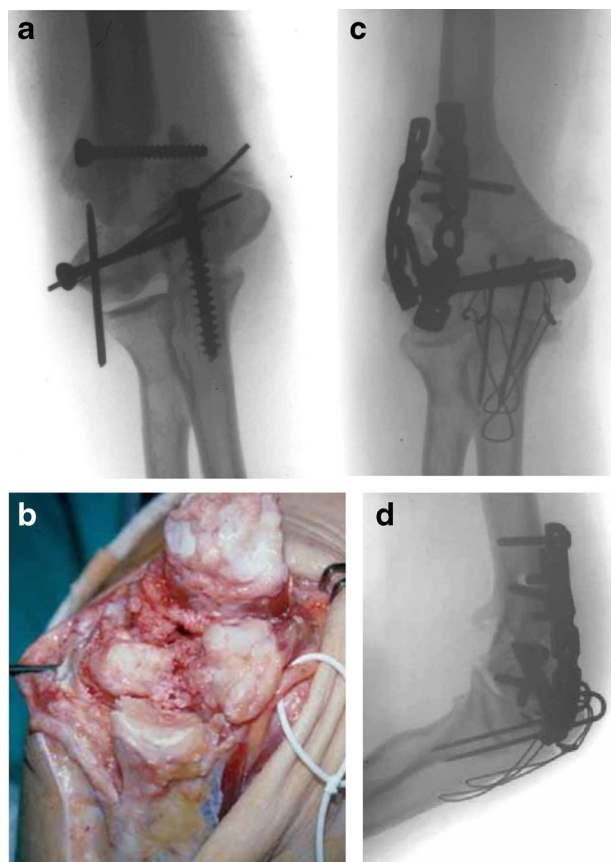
A 49-year-old woman with intra- and extra-articular nonunion of the distal humerus and contracture of soft tissue around the elbow. a Radiograph before revision surgery (anteroposterior view). b Image obtained during revision surgery. c Radiograph after revision surgery (anteroposterior view). d Radiograph after revision surgery (lateral view)
